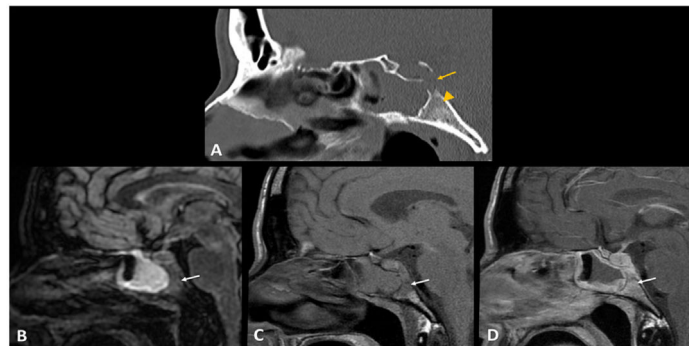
Clivus osteomyelitis: (A) Sagittal non-enhanced CT, bone window, demonstrates extensive cortical bone erosion and trabecular bone demineralization of the clivus and sella turcica. Sagittal fat-saturated T2WI FLAIR (B), pre-contrast T1WI (C) and post-contrast T1WI (D) shows high T2-signal, low T1-signal and heterogeneous enhancement of the clivus adjacent to the sphenoid sinus, in keeping with central skull base osteomyelitis.
